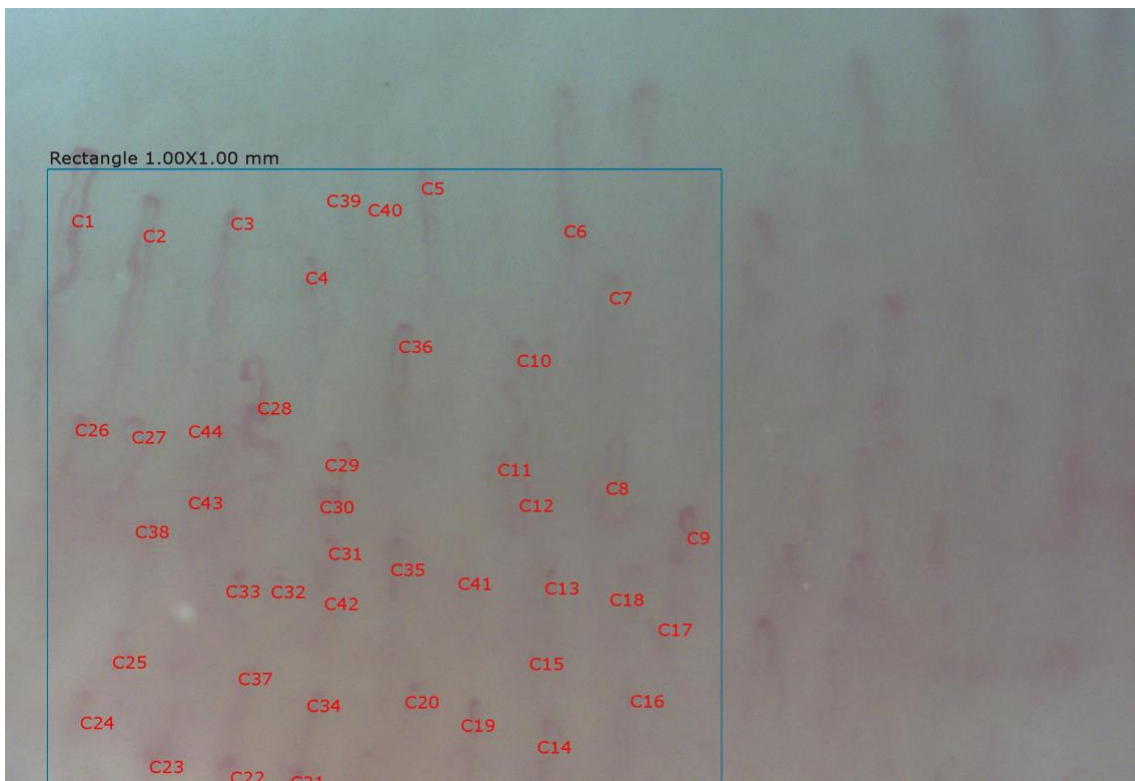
An image of nailfold capillaries taken using the INSPECTIS capillaroscope and counted manually on the associated software. This image was taken with a lens of 200x magnification.
